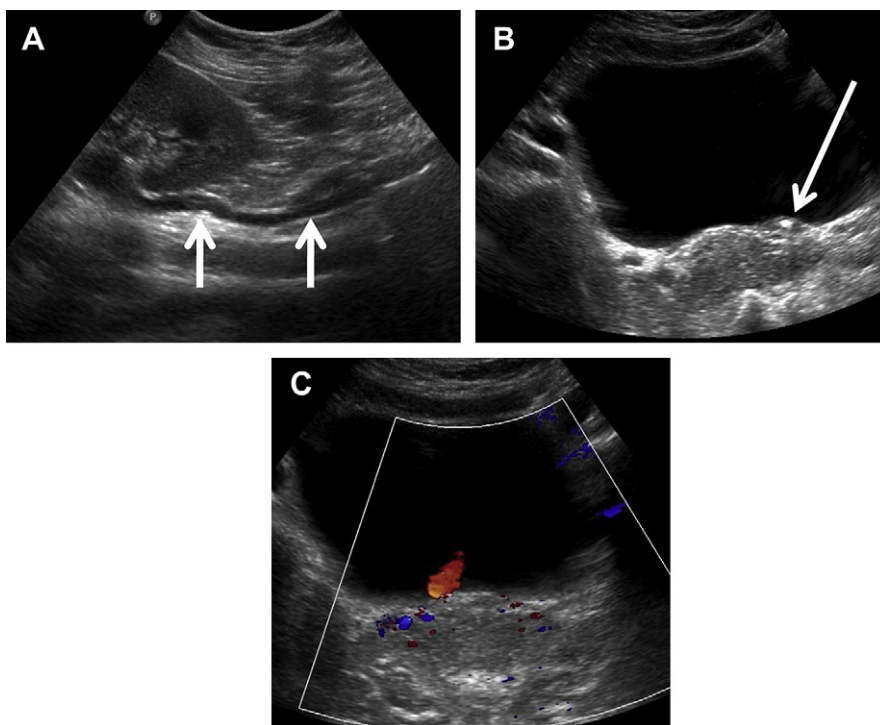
Acutely obstructing calculus at ureterovesical junction. (A) Longitudinal view of the lower of the pole left kidney shows dilated renal pelvis and ureter (arrows). (B) Transverse view of distended bladder with calculus at left ureteropelvic junction (arrow). (C) Transverse view of bladder with color Doppler only showed jets from right ureteral orifice.
